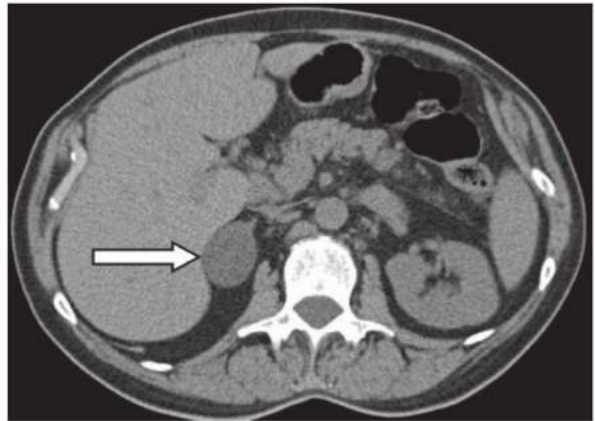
• CT scan of benign cortical adenoma.
